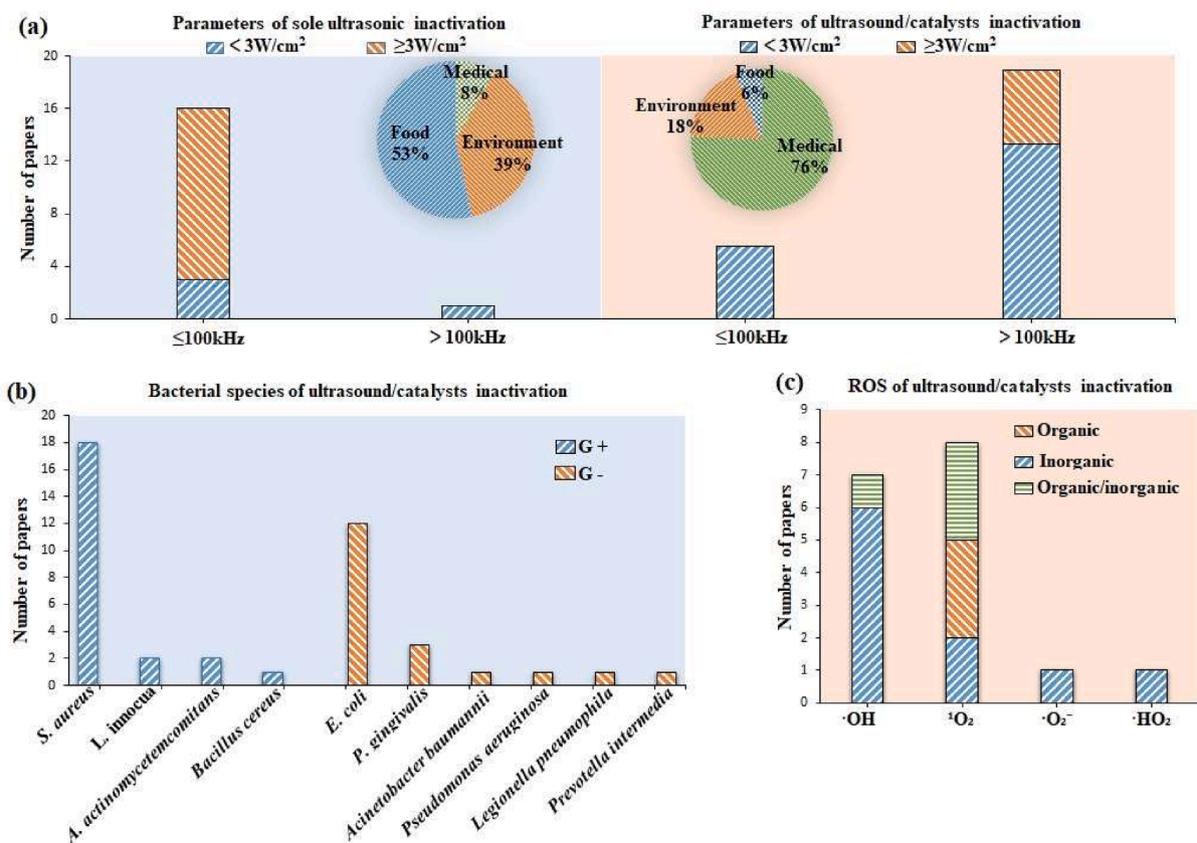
Published reports on ultrasonic inactivation of bacterial cells with/without catalysts. (a) Parameters of ultrasound used for inactivation. (b) Inactivated bacterial species. (c) Generated ROS by ultrasound/catalysts.
